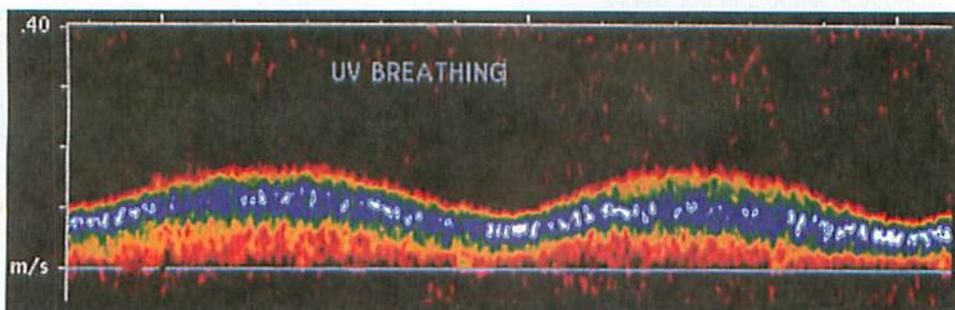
An ultrasound of the umbilical cord showing circulation.
